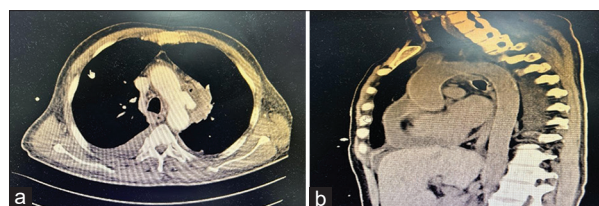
(a) Contrast-enhanced computed tomography (CT) showing aortic arch aneurysm - interruption of the wall of mid aortic arch with mycotic aneurysmal pouching (2.8 × 1.0 × 1.6)-adjacent collection with air pockets in the prevascular region, aortopulmonary window, and left perihilar region; (b) Sagittal CT – Aortic arch aneurysm
